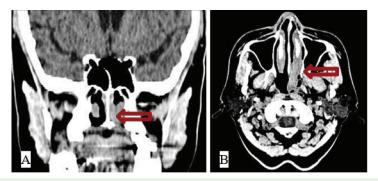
Computed tomography (CT) scan of paranasal sinuses; (A) Coronal view, (B) Axial view; CT scan revealed an enhancing mass in posterior left nasal cavity involving left inferior turbinate with protrusion into left sided nasopharynx, measured about 3.3×1.5×1.4 cm (arrow). No gross bony destruction is detected.
